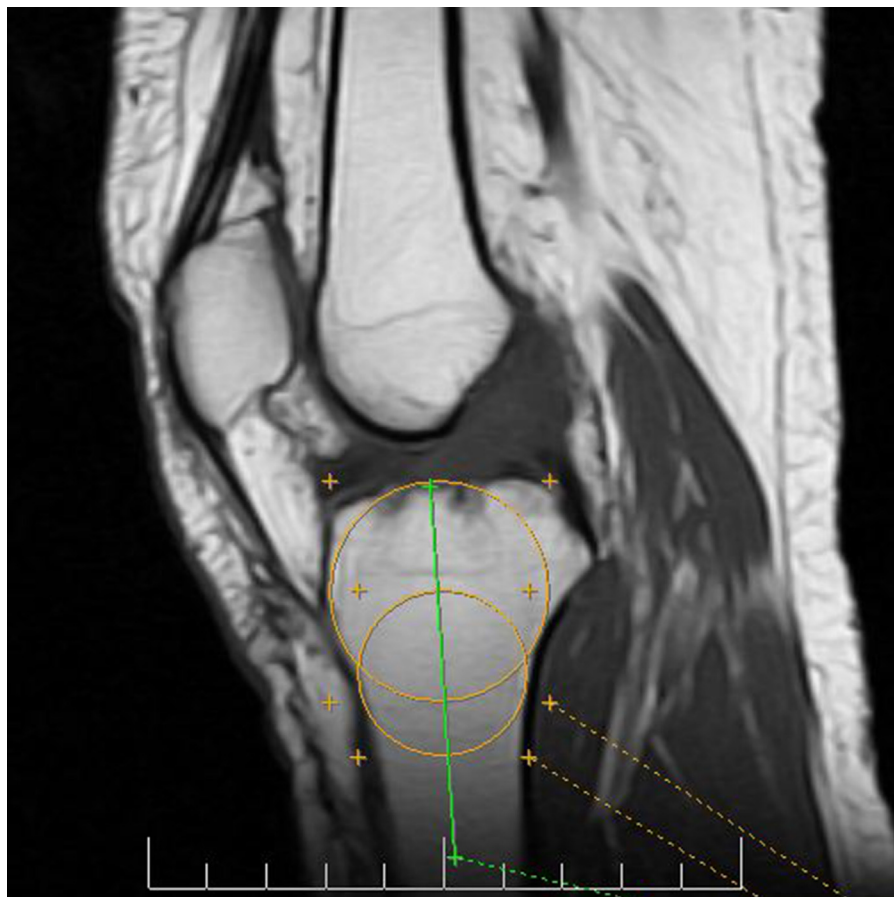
Sagittal section of intermediate weighted image of MRI showing method of determining longitudinal axis of tibia.
